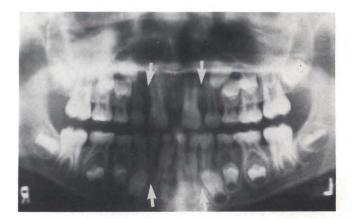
A radiograph of an eight-year-old male. All lateral incisors are missing.
